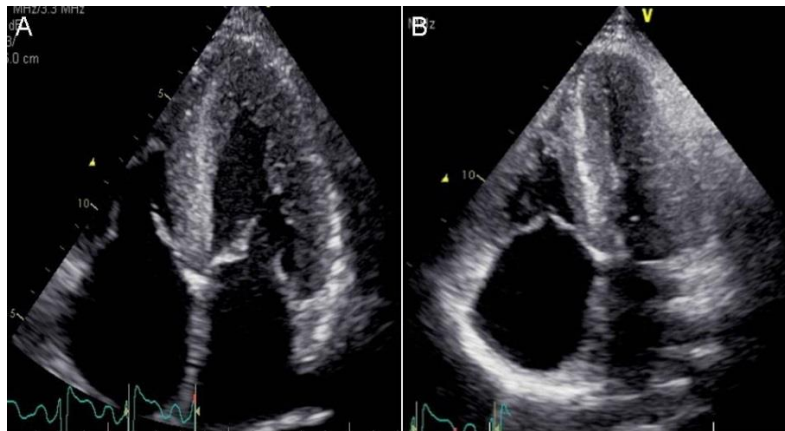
Representative apical 4 chamber echocardiographic views of the heart (diastole on the left and systole on the right).
